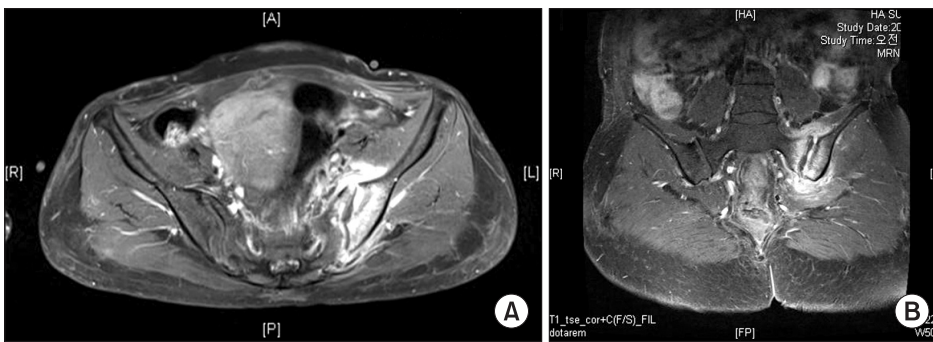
(A) Sacroiliitis of the left sacroiliac joint is seen with extensive osteomyelitis in coronal view of sacroiliac joint MRI. (B) Sacroiliitis of the left sacroiliac joint is seen with extensive osteomyelitis in sagittal view of sacroiliac joint MRI.
